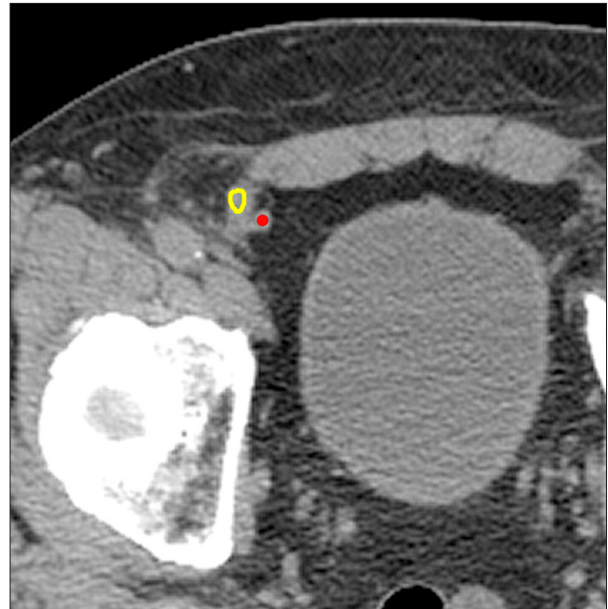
Amyand hernia. Color-coded CT image shows the appendix (yellow) within an Amyand's hernia. The indirect hernia originates superolateral to the course of the inferior epigastric artery (red). Reproduced from Burkhardt et al. [13] with permission from Radiographics. Copyright 2011.
